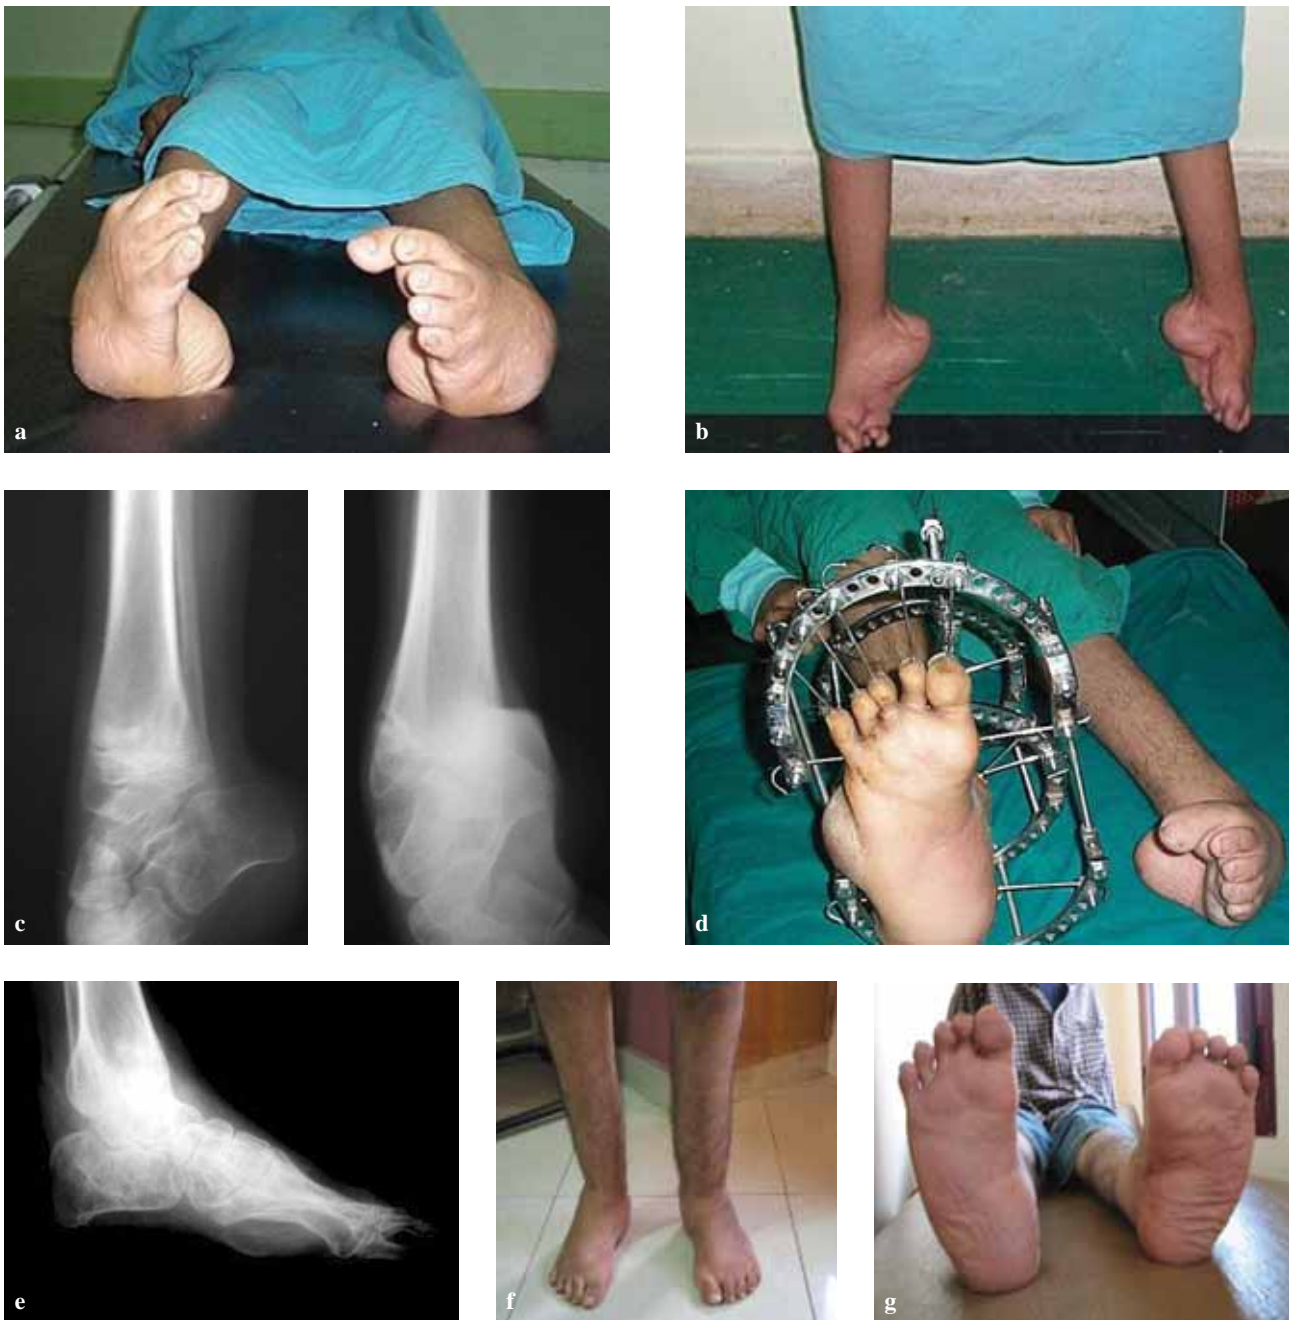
a and b) Preoperative appearance of the patient, c) Preoperative radiograph, d) Right side in the frame, e) Postoperative radiograph, f and g) After correction of both feet.
